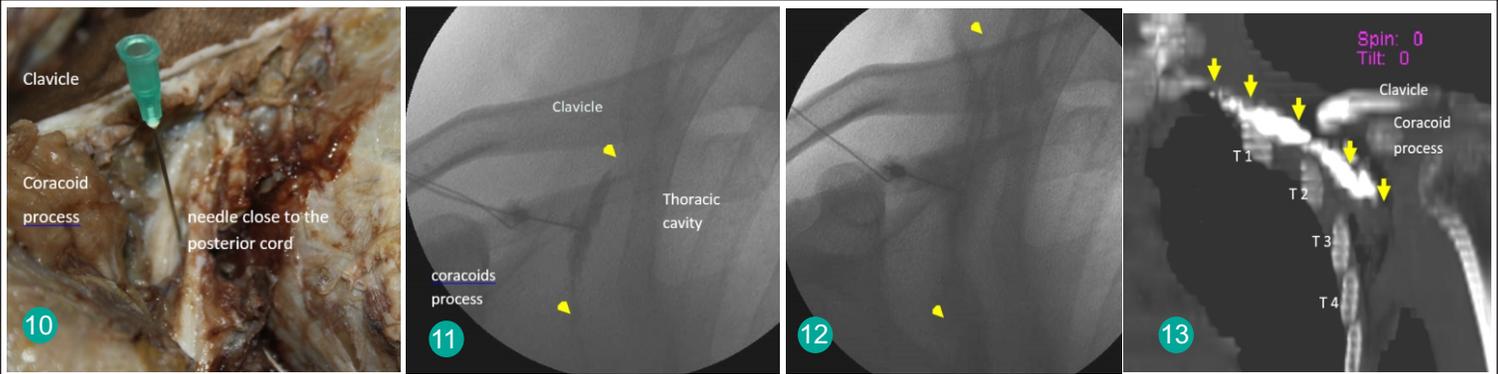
Needle placement close to the posterior cord. Fig 11 Cephalo-caudal spread of contrast. Contrast injected takes a direction cephalad and caudad to needle insertion. Fig 12 Cephalad spread of the contrast after 10ml LA. Fig 13 CT Contrast of the infraclavicular flow.
